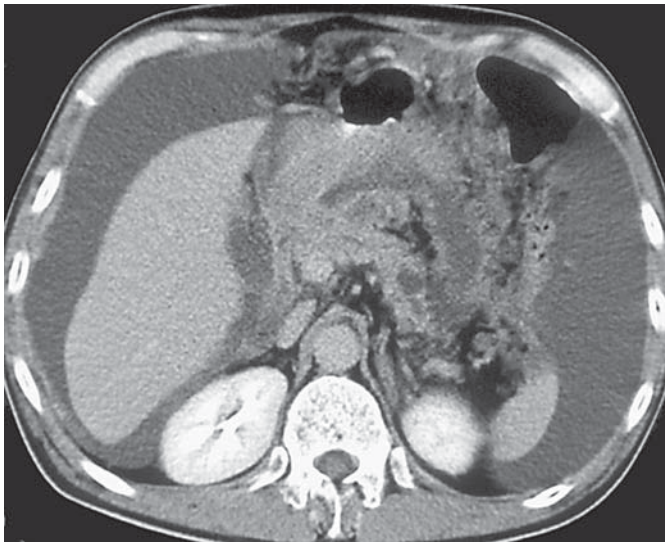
Computed tomography showing massive ascites, omental cake, thickened peritoneum, and cystic lesion of the pancreas.
